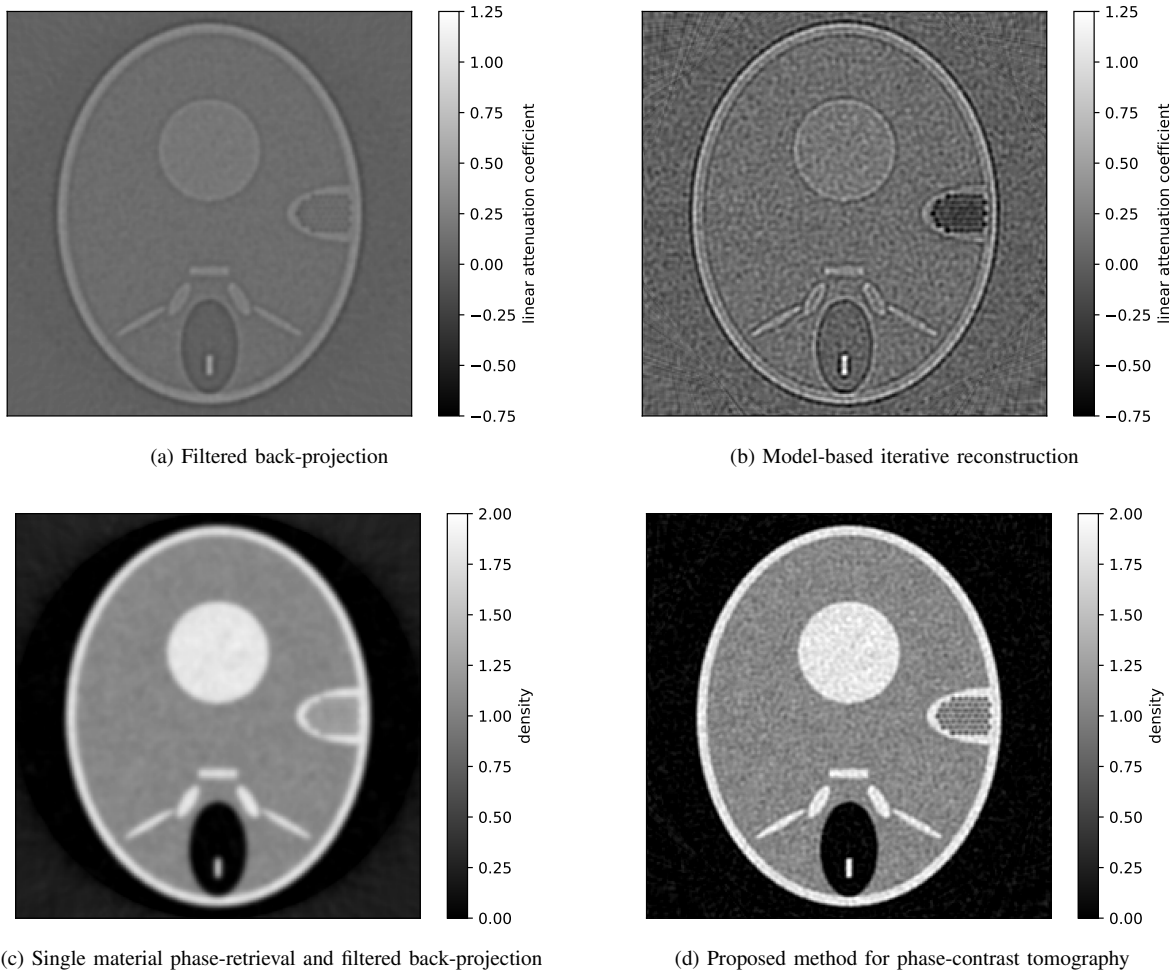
Comparison of different reconstruction approaches. The conventional filtered back-projection algorithm applied directly onto the measured intensities is depicted in (a). A model-based reconstruction approach, which includes models for source and detector into a statistical reconstruction algorithm, can be seen in (b). The conventional approach for propagation-based phase-contrast computed tomography is shown in (c). Thereby the traces under each angle are recovered with the single-material phase-retrieval algorithm. The retrieved traces are then tomographically reconstructed by means of the filtered back-projection algorithm. Finally the model-based algorithm, which additionally models the propagation of the x-rays, is shown in (d).
